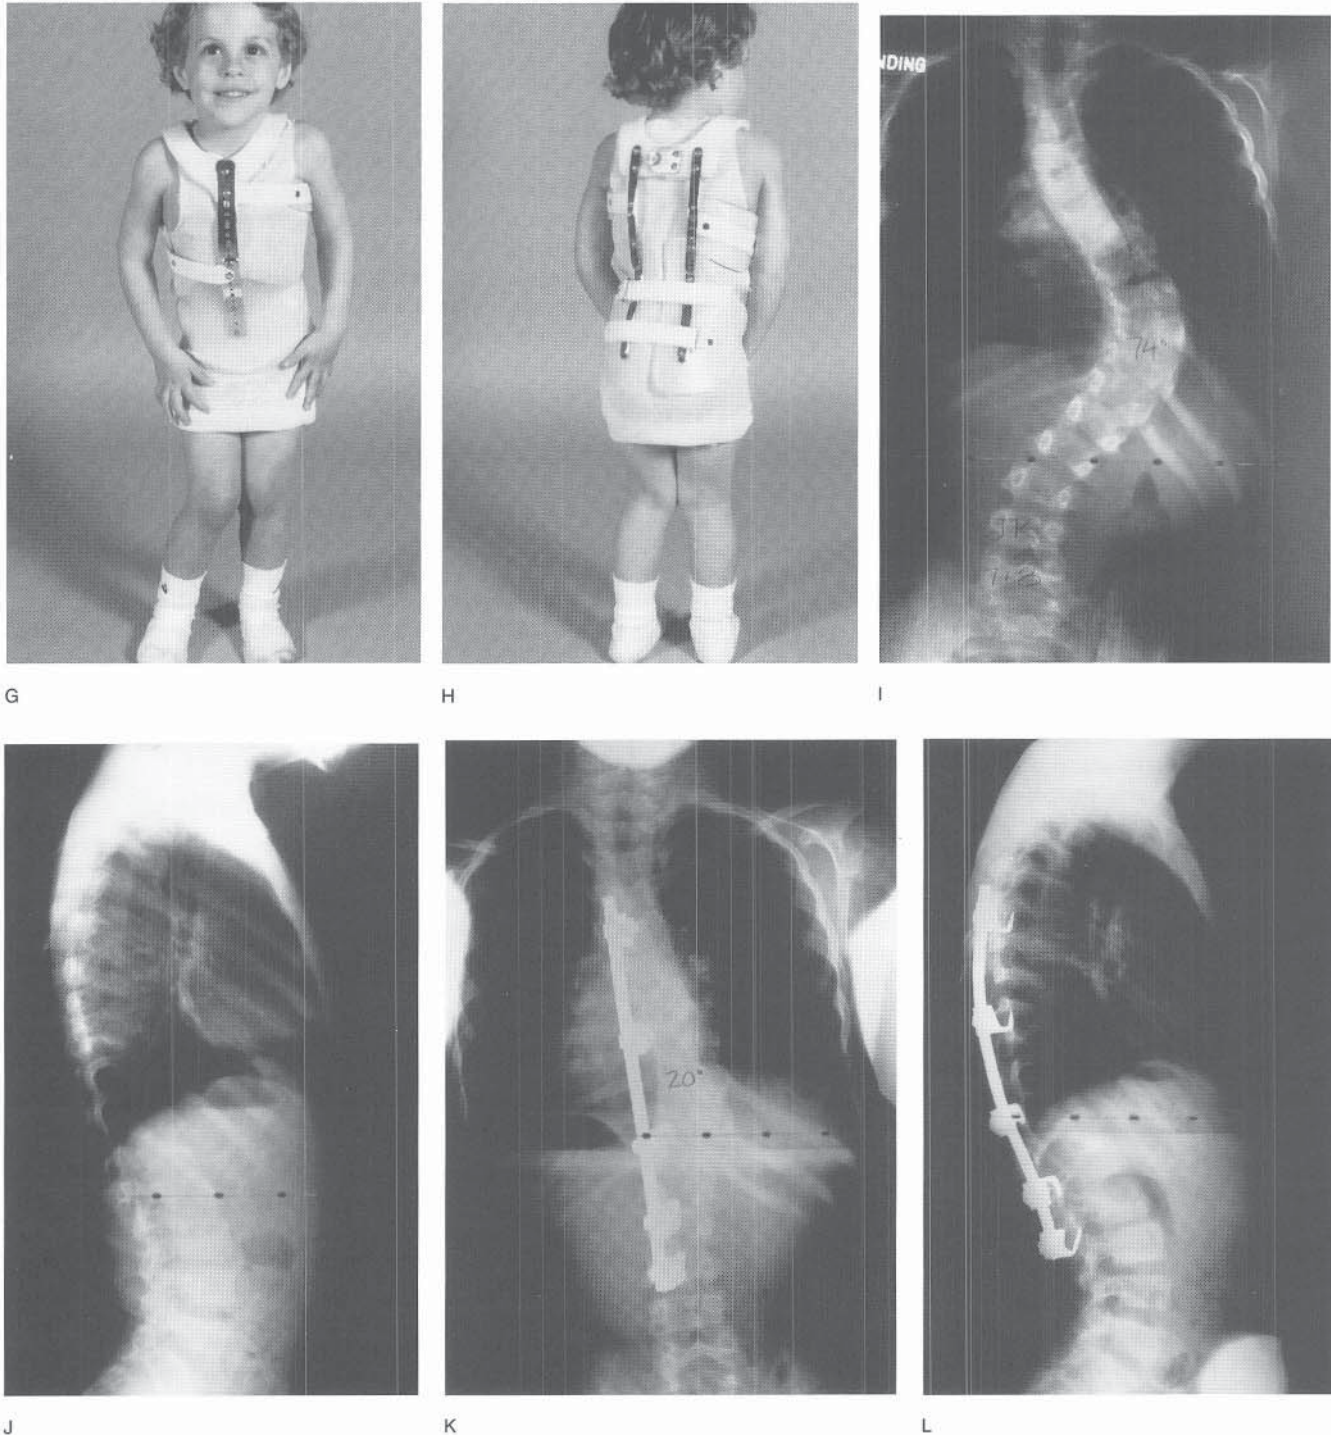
Continued.* Full-time use of a modified Milwaukee brace (F to H) during that time appeared to be beneficial. Unfortunately, despite compliance with the brace program, the curve increased to 74 degrees by age 7 years 10 months (I, J). Preoperative MRI was normal. Anterior diskectomy and fusion (T7-L1) followed by posterior instrumentation and fusion (T5-L2) was then carried out during the same anesthesia episode. One year later, the curve correction was maintained at 20 degrees and sagittal balance was normal (K, L). Aggressive nonoperative treatment usually allows surgery to be delayed until the child is 7 or 8 years old.
